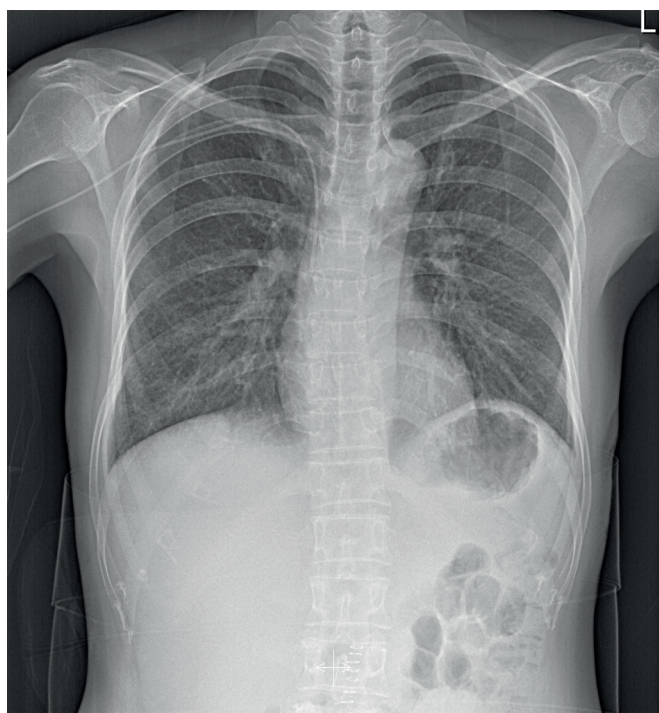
A follow-up chest radiograph on postoperative day 7 revealed that bilateral pleural effusions were completely resolved.
